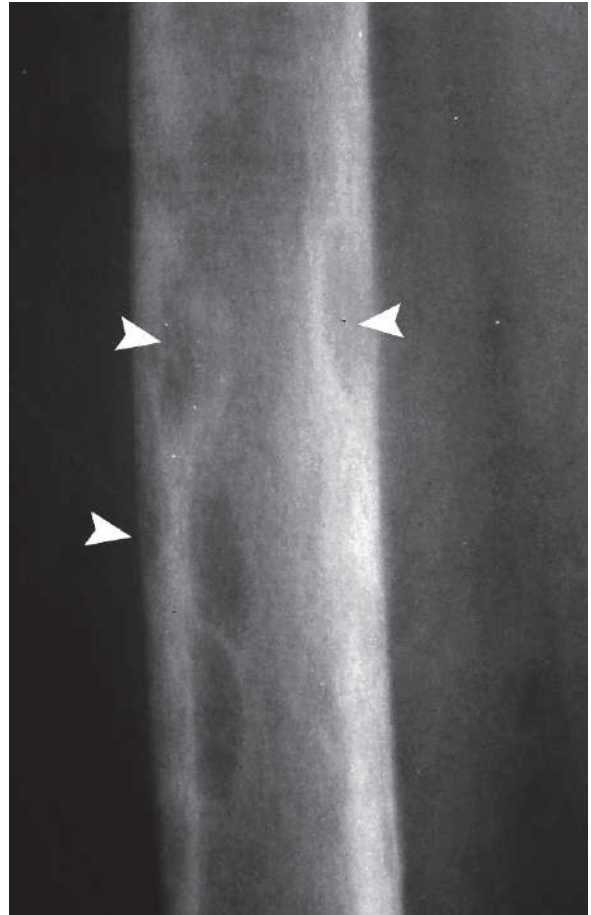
A plain radiograph of osteoporosis of the femoral shaft demonstrates clearly the intra-cortical tunneling sign (*arrowheads*)
